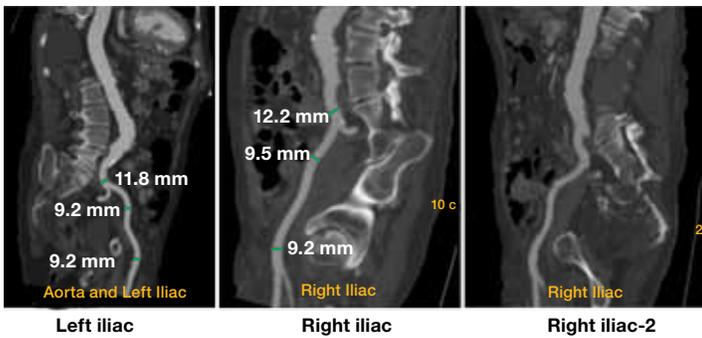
Curved multiplanar CT reformation and reconstruction using a centerline approach of the peripheral iliofemoral arteries and the entire aorta. Centerline image processing of the distal aorta and iliofemoral arteries allows measurement of the maximum and minimum arterial diameters at various levels as well as assessment of vascular dimensions, arterial calcification, and tortuosity of the vessels from the site of femoral puncture up to the aortic annulus. This figure shows an example of a 93-year-old male patient who was accepted for a transfemoral TAVI approach since he had adequate arterial sizes, paucity of calcification, and minimal vessel tortuosity.
